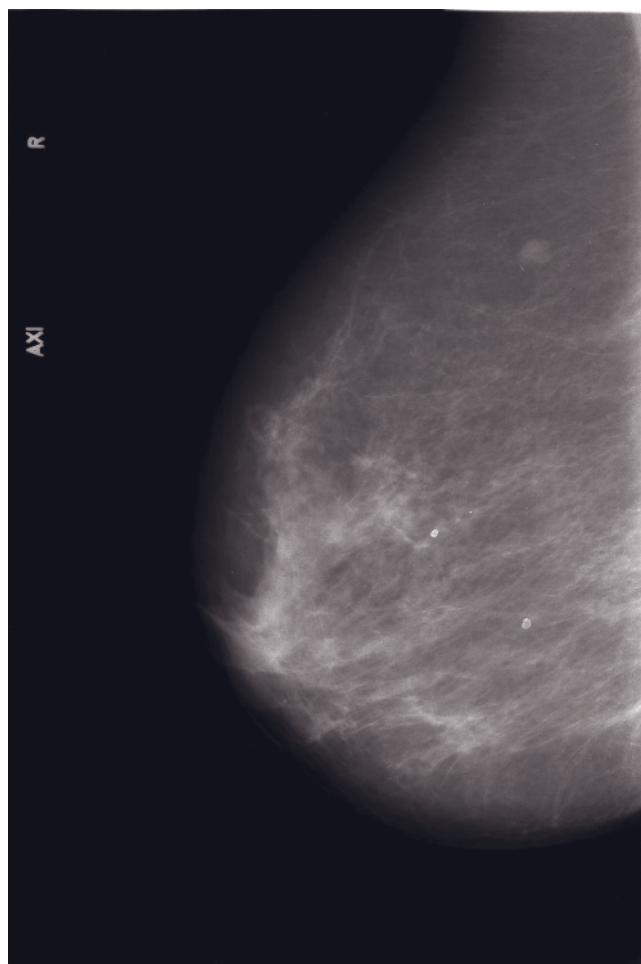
Lymph nodes. Reniform shape and fatty hilum on T2-weighted (a) and T1-weighted (b) images make the typical morphology of lymph nodes seen bilaterally in axillas. After application of GBCA, peripheral enhancement is usually present (c). Another case is depicted in d and e. ROI analysis of the postcontrast dynamic images (d) often shows rapid enhancement followed by an early washout, resulting in type III curve. Typical MR morphology or mammographic (e) appearance is suggestive of diagnosis.
